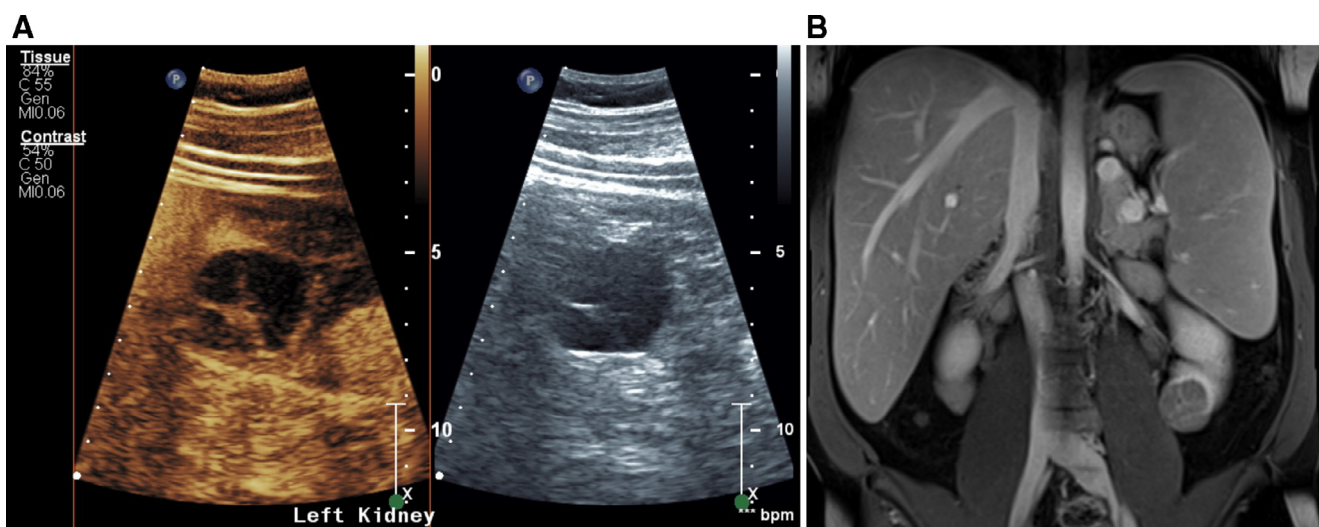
A 36-year-old female with a background of hereditary spherocytosis was found to have a Bosniak IIF cyst at the lower pole of the left kidney. During follow-up, the number and thickness of septations increased, re-classifying the lesion as Bosniak III. (a) CEUS showing florid septal enhancement with marked thickening on the 3.3 cm lesion. (b) Coronal post-contrast T1w fat-saturated MRI confirming the findings of a Bosniak III lower pole renal cyst. Incidental hepatosplenomegaly is due to hereditary spherocytosis. The lesion was resected by partial nephrectomy and was found to be a Fuhrman grade I clear cell RCC.
